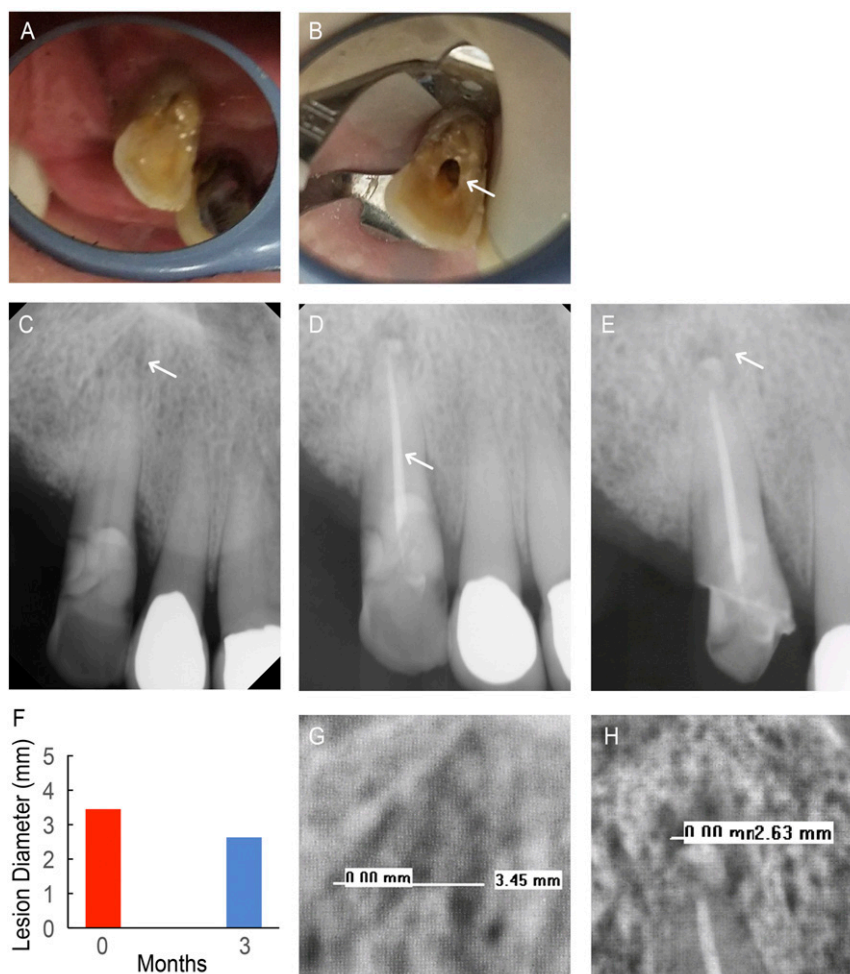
NDGP-treated patient 2 (ND2). (A) Pretreatment clinical image of tooth 6. (B) Clinical image of access cavity (white arrow). (C) Pretreatment radiograph with existing periapical lesion (white arrow). (D) Completed obturation with unmodified GP apical seal, NDGP backfill, and unmodified GP coronal seal (white arrow). (E) Three-month follow-up radiograph with healing periapical lesion (white arrow). (F) Lesion diameter at pretreatment (red) and 3-mo follow-up (blue) appointments. (G) The 3.45-mm lesion diameter was visible on the pretreatment radiograph. (H) The 2.63-mm lesion diameter was visible on the 3-mo follow-up radiograph.
